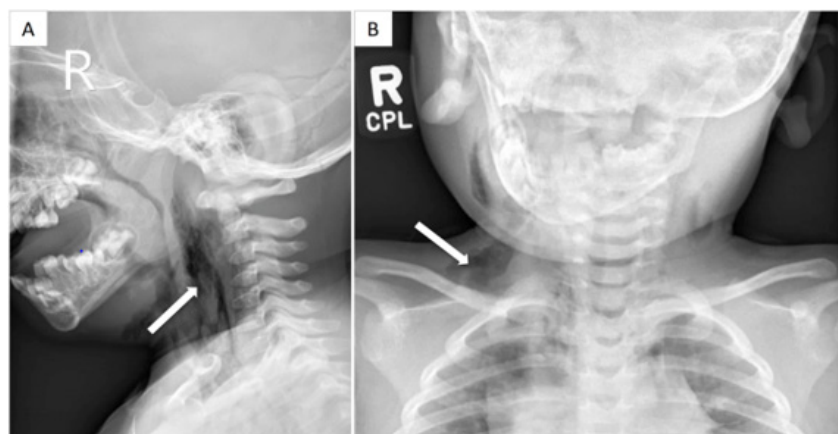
Neck (A) and chest (B) radiographs showing retropharyngeal and subcutaneous emphysema (arrows) tracking along bilateral facial and neck planes, predominantly the right carotid and supraclavicular region, and inferiorly into the mediastinum.
